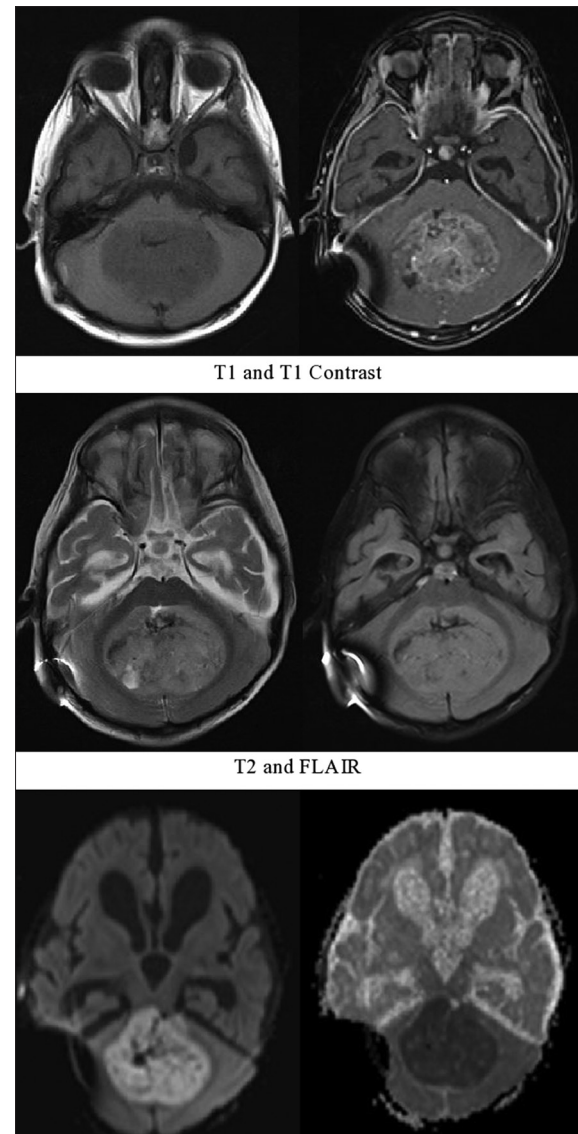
T1-weighted images, T1-weighted images contrast, T2-weighted images, fluid-attenuated inversion recovery, diffusion-weighted imaging, and apparent diffusion coefficient mapping. 7 years aged male child presents with a history of increase in the size of head since 6 months. Also, c/o blurring of vision, weakness of upper and lower limbs, unable to walk with high-stepping gait with one episode seizure. Magnetic resonance imaging shows a large well defined T1-weighted images hypointense and T2-weighted images/fluid-attenuated inversion recovery iso to hyperintense, heterogeneously enhancing lesion in the fourth ventricle showing restriction on diffusion-weighted imaging (mean apparent diffusion coefficient of $0.511 \times 10^{-3} \text{ mm}^2/\text{s}$). Biopsy report: Medulloblastoma - WHO Grade IV
